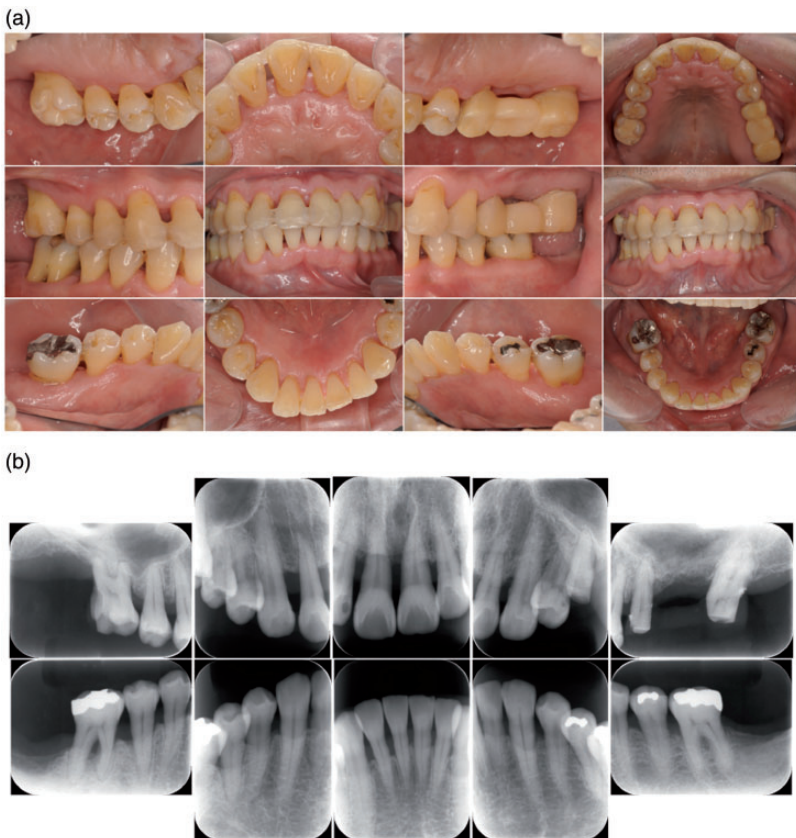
Oral view and radiographic images after basic periodontal treatment. (a) Intraoral images taken after basic periodontal treatment. (b) Radiographic images taken after basic periodontal treatment.
